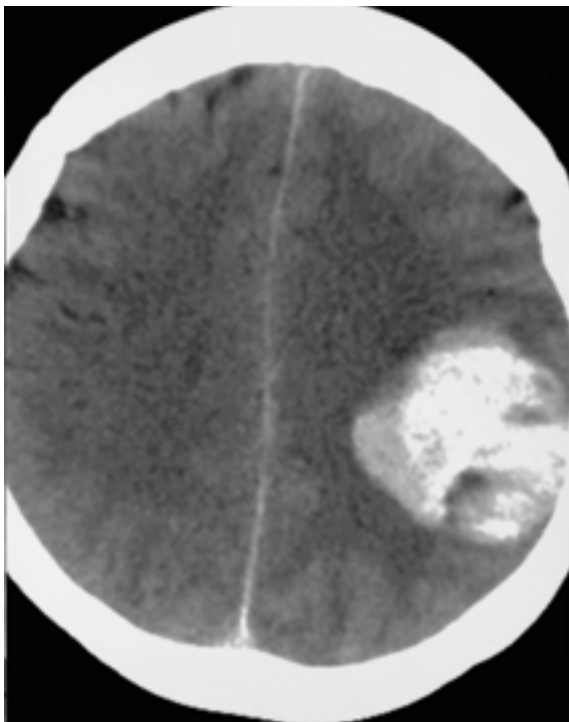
After catheter-directed thrombolysis, acute stroke was developed and brain CT shows acute intracranial hemorrhage in left temporoparietal lobe.
